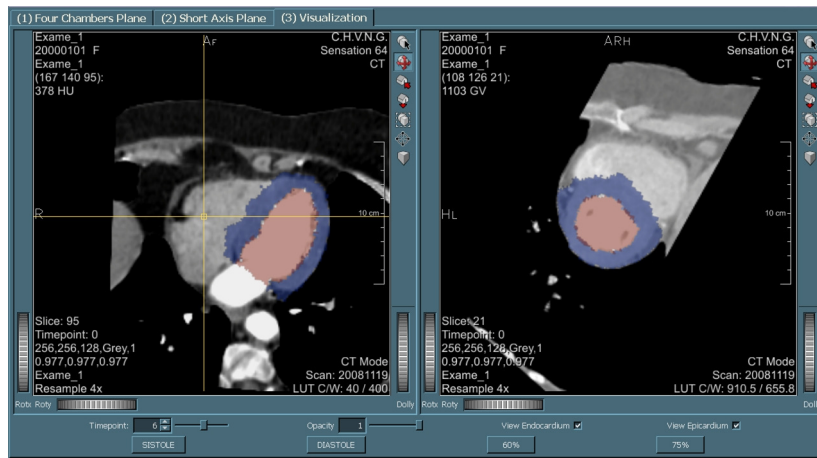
User interface of the application developed using MeVisLab to support the preliminary evaluation process. Endocardium and LV wall segmentations are visualized in a 4-chambers view (on the left) and in a LV short-axis view (on the right) defined by the radiographer on the first evaluation step.
